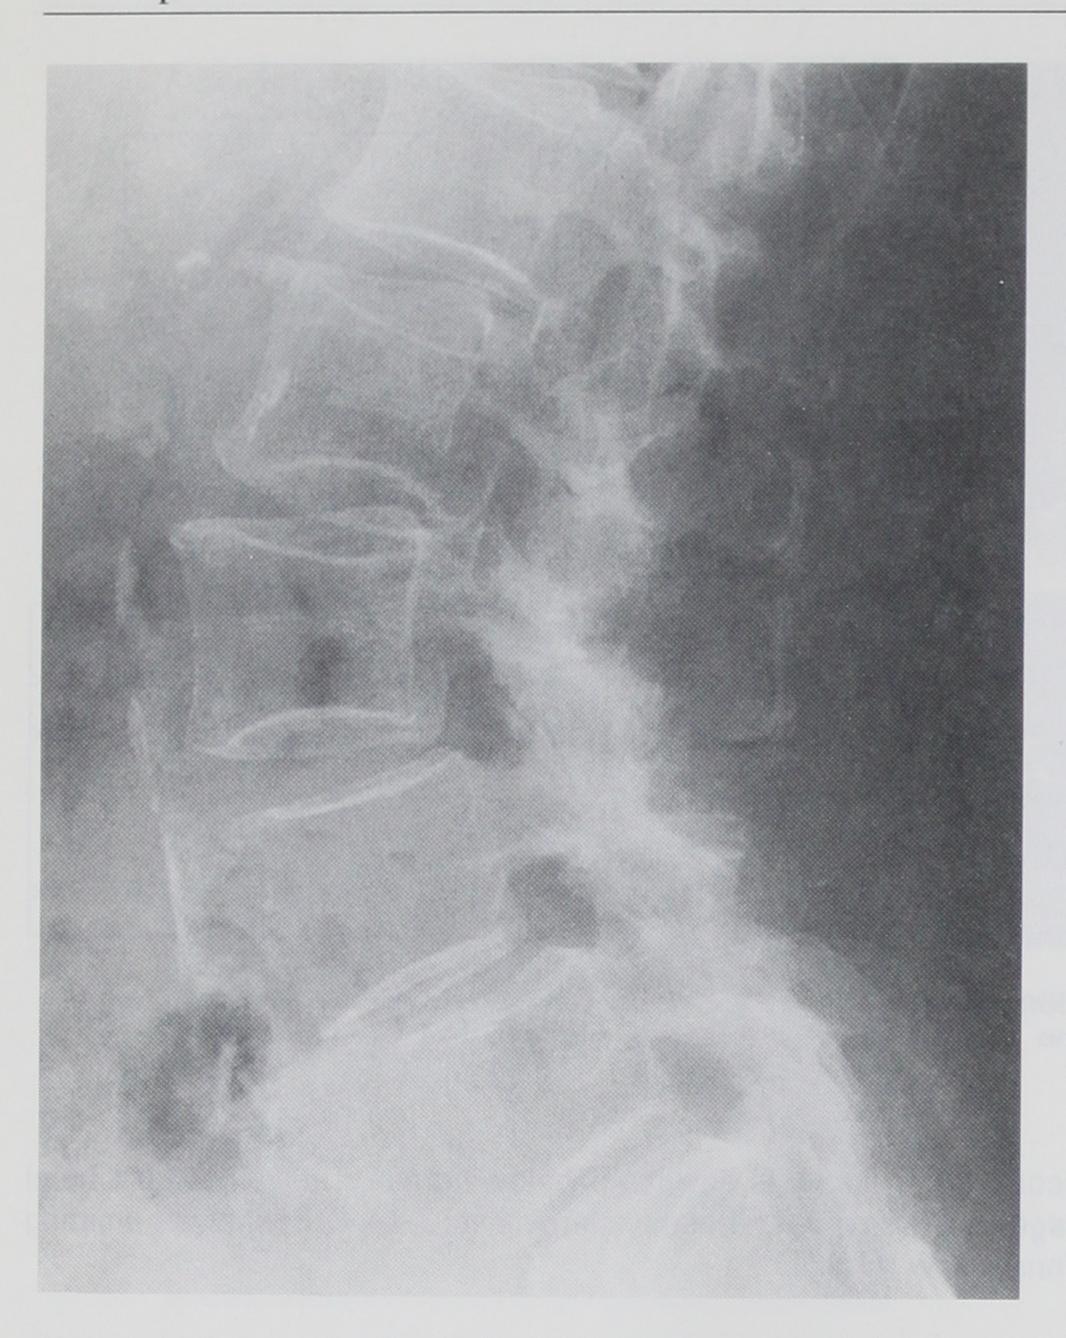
Lateral radiograph of the spine. The vertebral bodies are severely osteopenic. The aortic calcification anteriorly and severe osteoarthritis of the facet joints posteriorly would significantly elevate a bone density measurement done in the posteroanterior projection.
